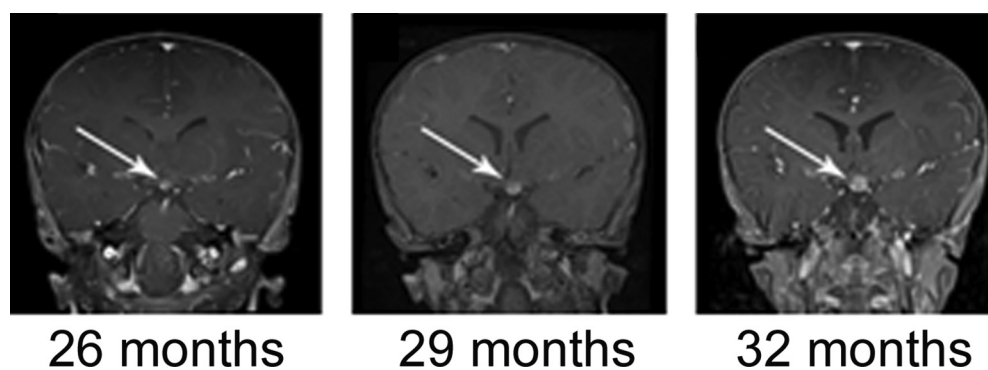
Neuroimaging reveals radiographic progression of the hypothalamic glioma. Coronal reconstructions of serial contrast-enhanced T1-weighted brain MRI scans, demonstrating progression of contrast enhancement in the left hypothalamic glioma (arrows) at 26, 29, and 32 months of age.
